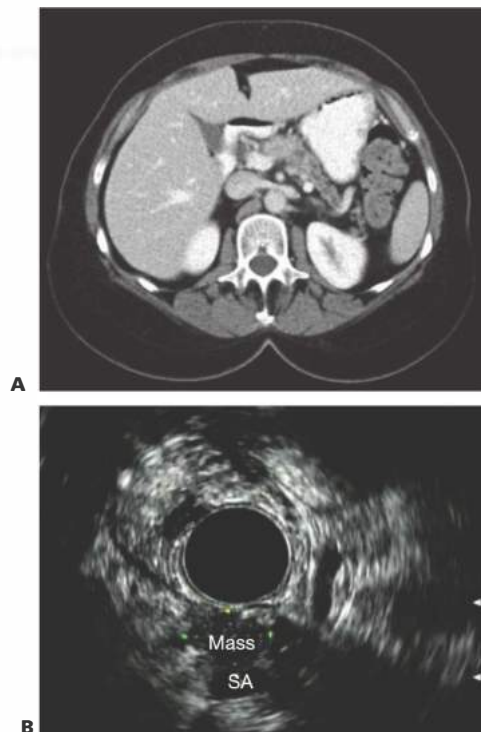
● A. Venous-phase CT showing a hypodense mass in the pancreatic body adjacent to the splenic artery. The distal pancreatic duct is dilated. B. EUS showing the pancreatic body mass with direct abutment with the splenic artery (SA).
